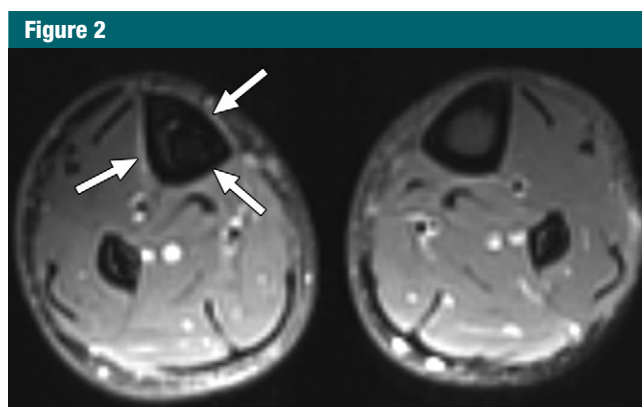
Axial STIR MR images (5000/41; section thickness, 5 mm) at the level of the midcalf show subtle periosteal reaction surrounding the right tibia (arrows), seen as an area of thin circumferential hyperintensity consistent with a grade I stress reaction.
